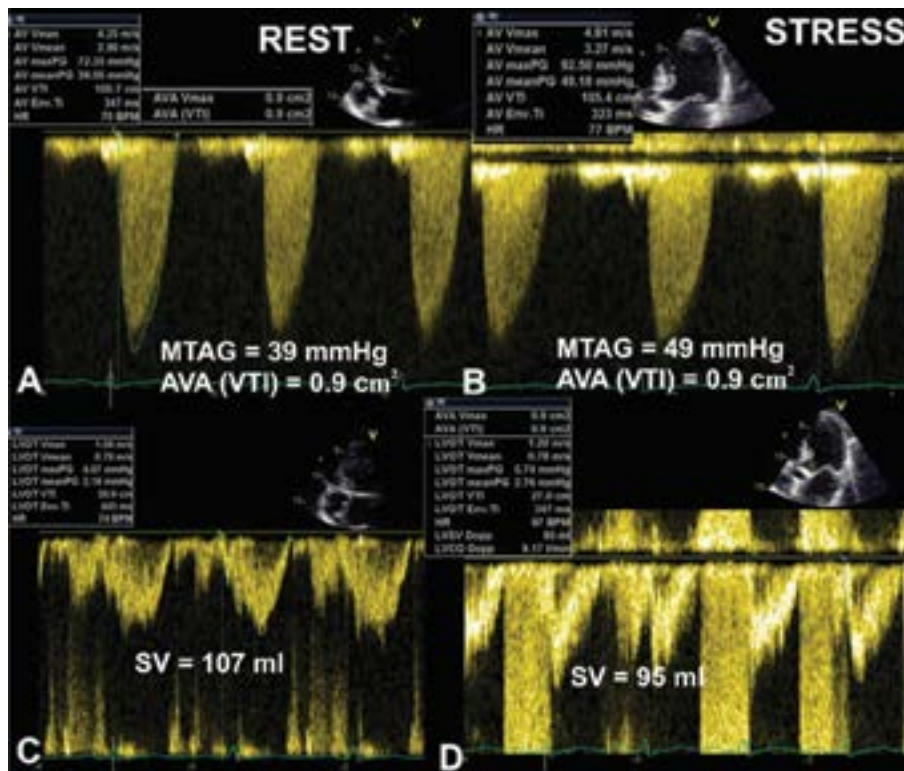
Doppler findings at rest (left panels) and at exercise (right panels) obtained while performing EE in asymptomatic patient with severe AS. Although increase in MTAG was ~10 mm Hg (nonsignificant) (A and B), exercise-induced dyspnoea, decrease in LVEF (from 55 to 45%) and SV by 12 mL (C and D) and increase in trans-tricuspid gradient (from 45 to 79 mm Hg) were observed, all of which represent haemodynamically significant symptomatic AS. The patient underwent surgical AVR; AV – aortic valve; AVA – aortic valve area; AV Env; Ti – aortic time interval; HR – heart rate; LVCO – left ventricular cardiac output; LVOT – left ventricular outflow tract; LVSV – left ventricular stroke volume; maxPG – maximal pressure gradient; meanPG – mean pressure gradient; MTAG – mean trans-aortic gradient; SV – stroke volume; SVI – stroke volume index; Vmax – maximal velocity; Vmean – mean velocity; VTI – velocity time integral
